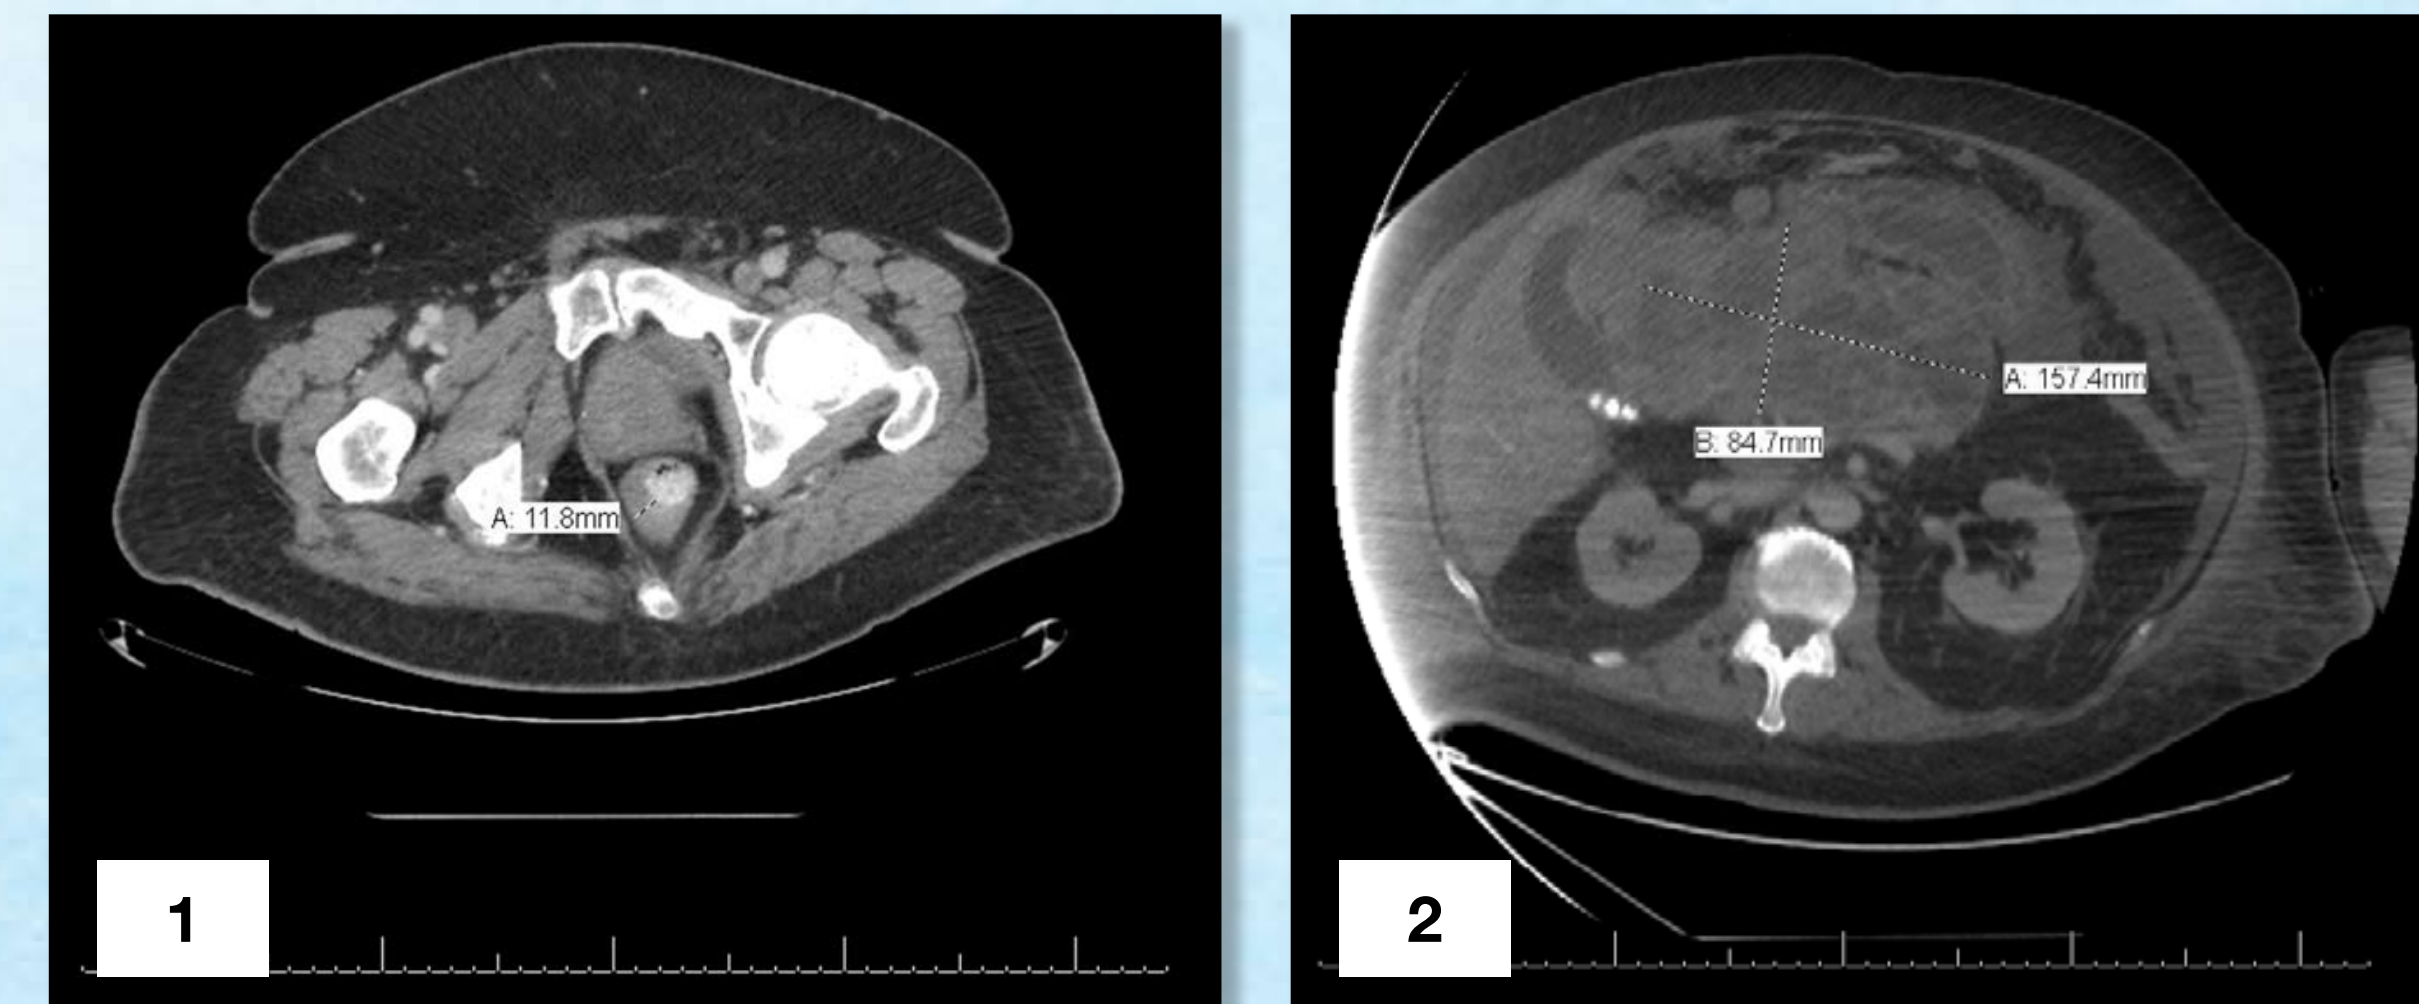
Sagittal view of CT scan abdomen and pelvis with contrast demonstrating circumferential rectal wall thickening suggesting a mass measuring up to 11.8mm in thickness.
